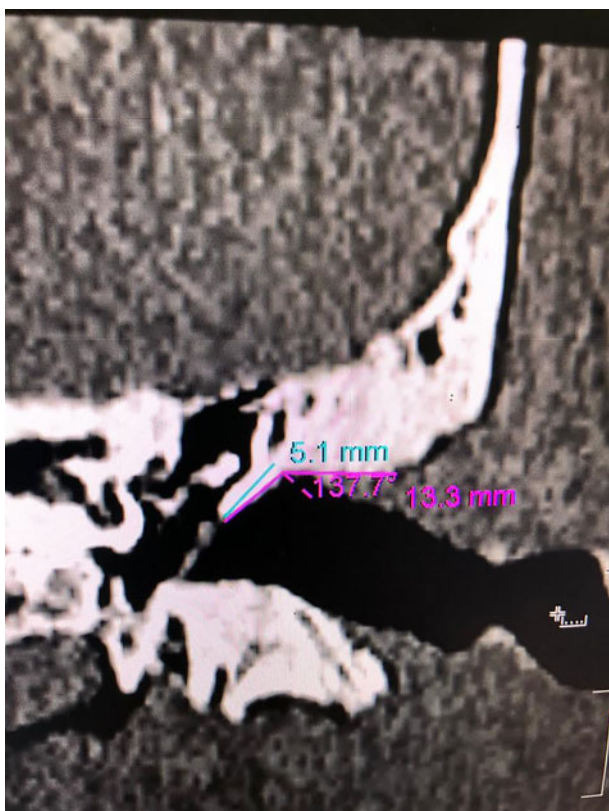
The left coronal cut of the pre-operative high-resolution computed tomography image shows a completely inaccessible stapes footplate (type II), angle 137.7° and length 5.1 mm.
